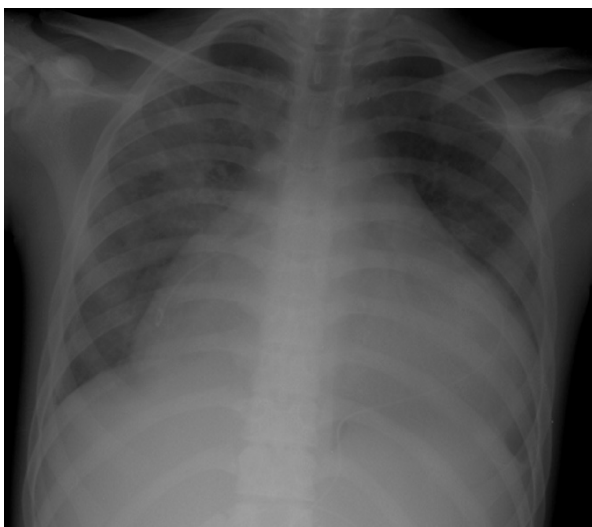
Case 2. Left: Chest X-ray at our tertiary hospital showed a water bottle shape indicating a massive pericardial effusion. Right: Chest X-ray on the 16th day of care after pericardial window showed marked improvement of effusion.
